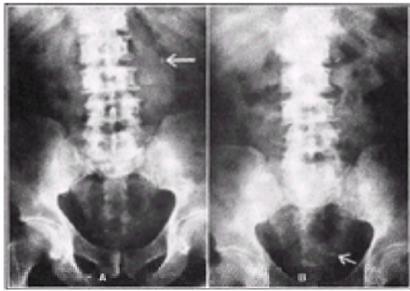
A: Radiograph of a patient with a stone in the left ureter at the level of the second lumbar interspace (arrow), which produced severe colicky pain in the left flank with radiation to the left groin, testicle, and inner aspect of the thigh. The stone did not advance for 48 hours, and the pain persisted despite repeated administration of narcotics. Paravertebral sympathetic block of T-10 to L-2 caused complete relief of pain and permitted the patient to be up and about. The nerve block was repeated in 12 hours. B: Radiograph taken after second nerve block showing that the calculus had descended to the ureterovesical junction (arrow). From this position, it was extracted with cystoscopic manipulation.
